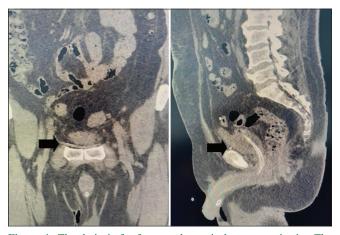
The drain is far from urethrovesical anastomosis site. The urethral Foley catheter is in bladder. Non-contrast CT images had normal early postoperative appearance
